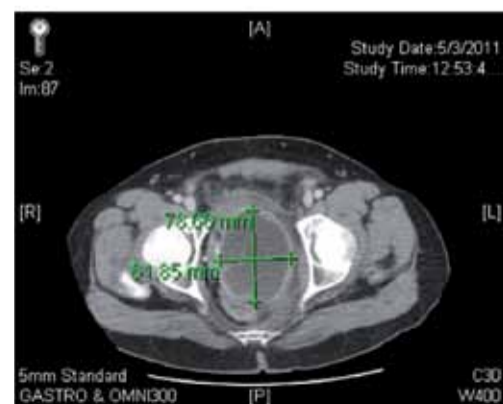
Patient A: CT scan showing prostate fluid collection.
